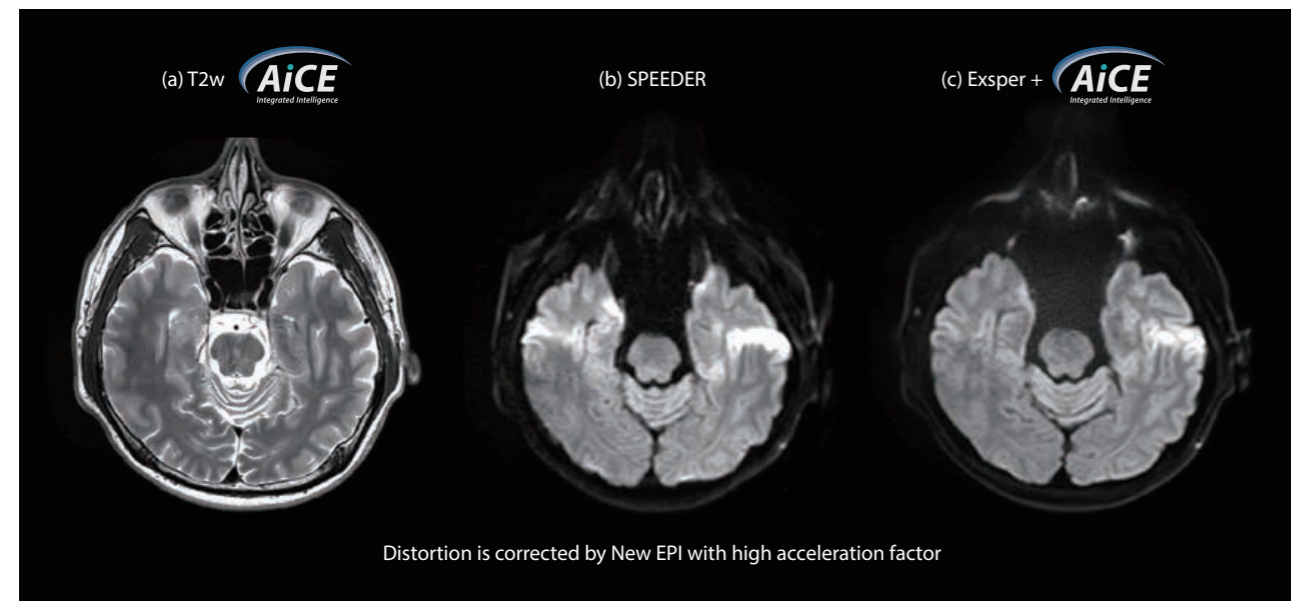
Comparison between DWI image with SPEEDER and Exsper+AiCE. Exsper helps to correct distortion with higher acceleration factors (a) T2w + AiCE (b) SPEEDER x2 (c) Exsper x 6 + AiCE
